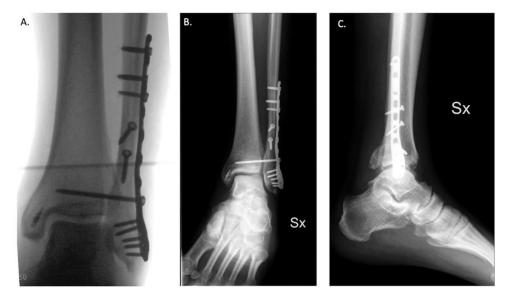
Intra-operative fluoroscopic anteroposterior view (A) of the left ankle after open reduction internal fixation with plate and screws, trans-syndesmotic fixation, and DL repair with 5 mm anchor. The 1-month X-ray anteroposterior (B) and lateral (C) views show excellent mortise anatomy reduction and restoration.
